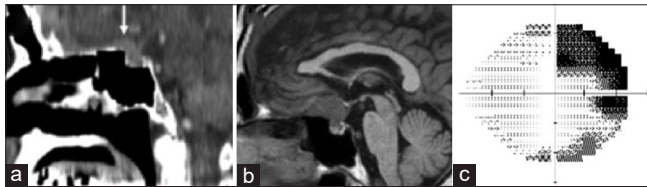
(a) A high-density mass was seen on sagittal computed tomography in 2017 (white arrow). (b) T1-weighted sagittal image with iso-intensity showing the tumor located at the tuberculom sellae. (c) When the suprasellar tumor was initially found, the patient's visual field test on the right eye showed upper temporal quadrantanopsia.
